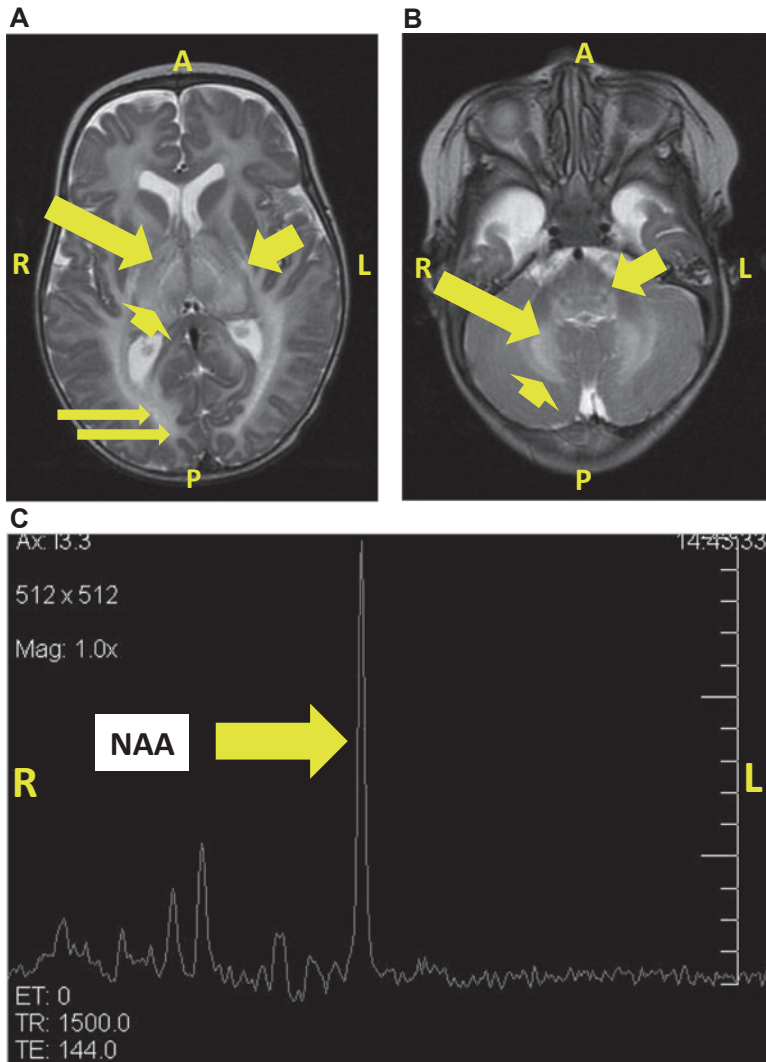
(a) Magnetic resonance imaging (MRI) of the brain in a baby with Canavan disease (CD) (R, right; L, left; A, anterior; P, posterior). Axial T2 at the level of the basal ganglia shows abnormal signal in the thalamus (arrowhead) and globus pallidus (arrow) bilaterally as well as focally in the posterior limbs of the internal capsules (short arrow) and the posterior deep white matter (double arrow). Characteristic sparing of putamina, claustrum, caudate, corpus callosum, and most of the internal capsules
